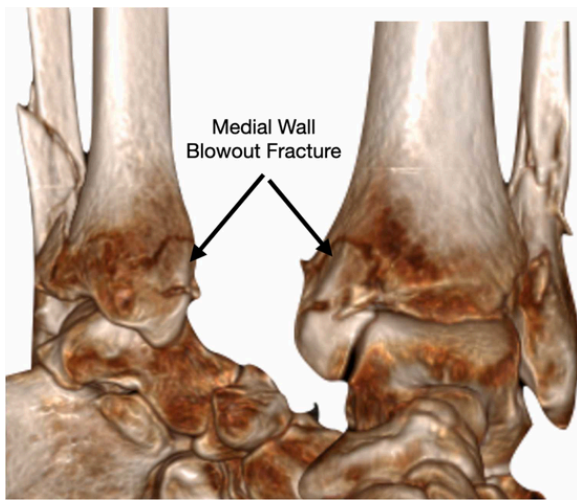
Medial wall blow out as displayed on a 3D CT surface rendering of an ankle.
